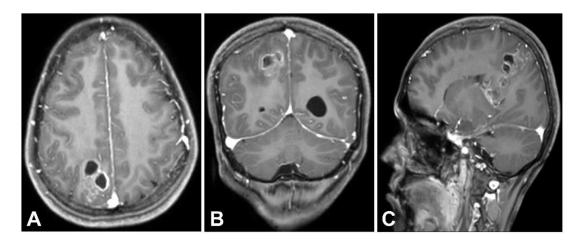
Axial, coronal, and sagittal MRI T1+C sections showing a heterogeneously enhancing lesion in the right parietal region.
